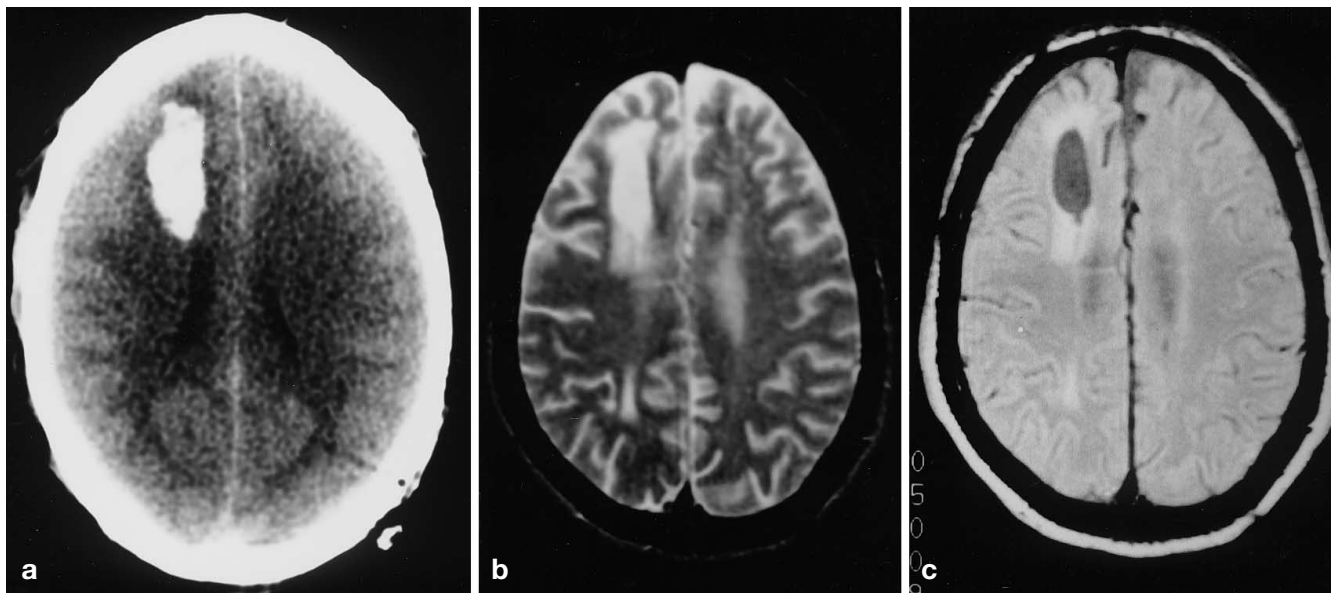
A large, sharp-edged, dense haematoma which “disappeared” a CT 4 h, b,c T2- and PD-weighted MRI 1 year after injury. Note that despite the size and density of the haematoma, (which is not unlike some spontaneous haemorrhages in appearance) there is no haemosiderin rim on late MRI
